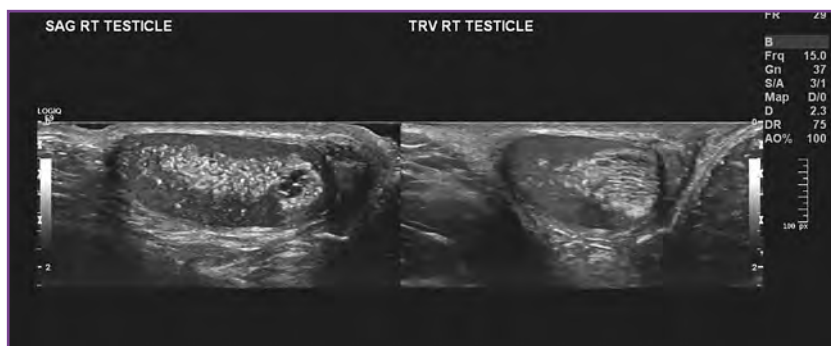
Ultrasonographic images of cystic dysplasia of the right rete testis in a 2-year-old boy with a history of right multicystic dysplastic kidney and recent “scrotal swelling.”
